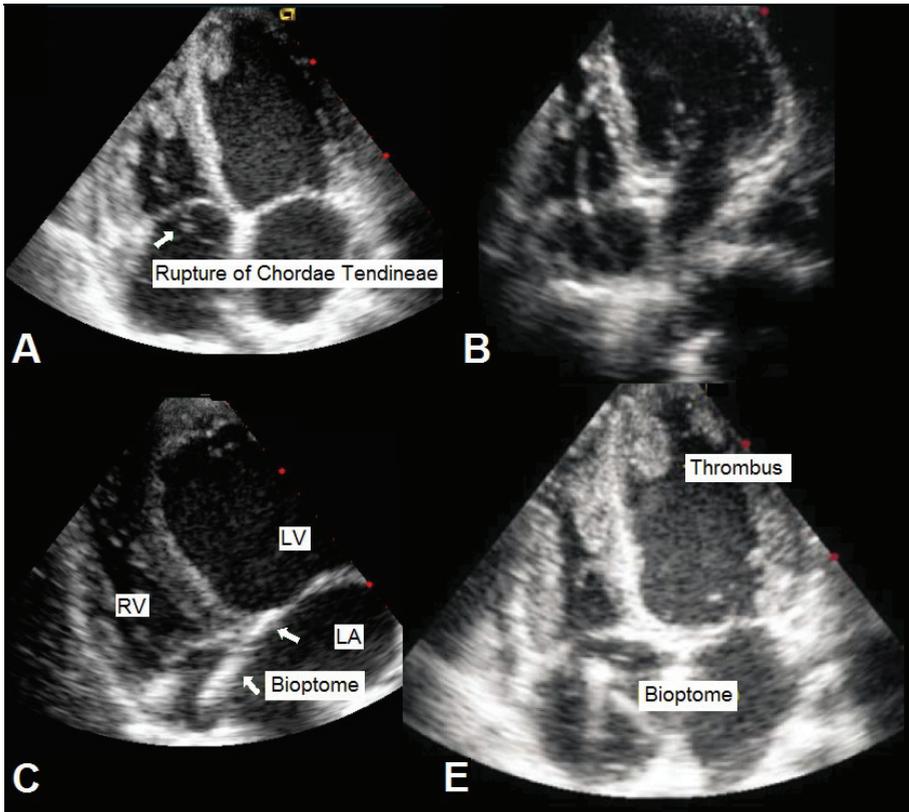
A - Rupture of chordae tendineae due endomyocardial biopsy. B - Bioptome in normal position toward the interventricular septum. C - Bioptome inside coronary sinus. D - Bioptome in normal position inside right atrium and left intraventricular thrombus finding echocardiographic
